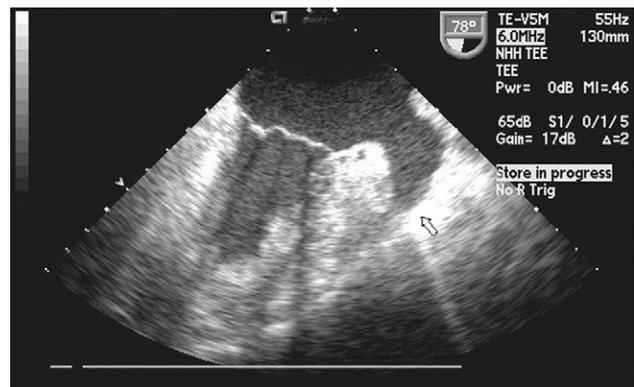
Left atrial appendage as seen on transesophageal echocardiography before occlusion (arrow).
